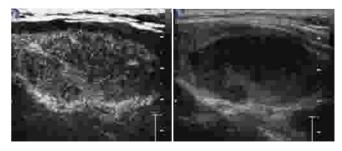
Contrast-enhanced ultrasonography shows a ringenhancement at the border of the nodule at the washout phase.
